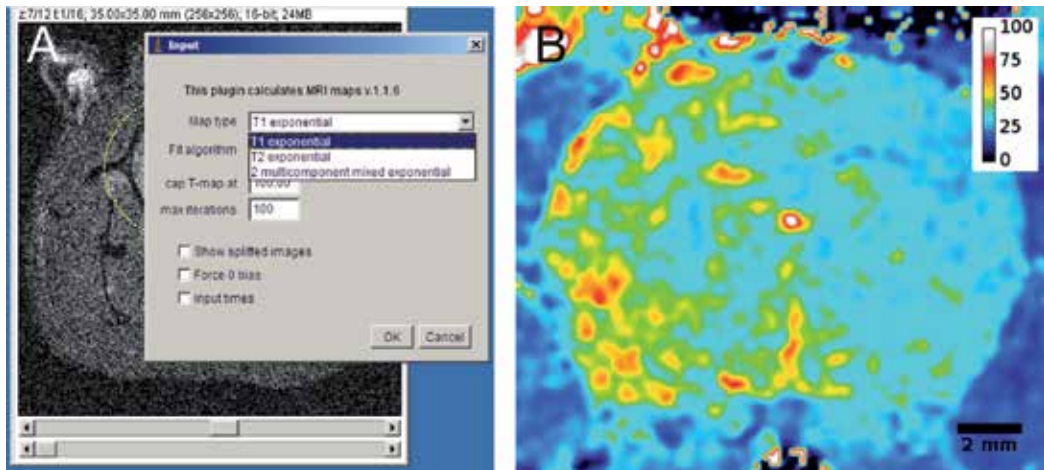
Operation of the MRI Processor plugin
